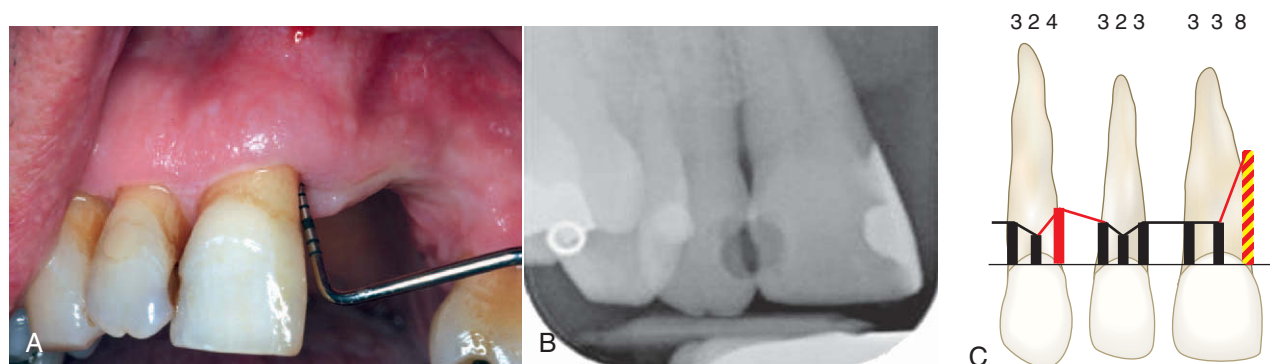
• Preoperative laser data collection of patient with severe periodontitis and major osseous resorption of maxillary central. A, Clinical probing; B, radiograph; C, periodontal charting. Patient has used removable dental appliance for several years. No symptoms, but pocket depth for maxillary right central was 8 mm, with angular osseous defect at the base of the lesion.
